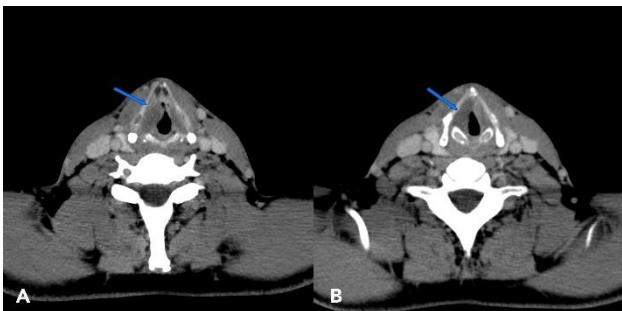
CT scan (axial views) at presentation showing an infiltrative hypodense mass (arrow) in the right paraglottic space (A) with extension to subglottic area (B).
